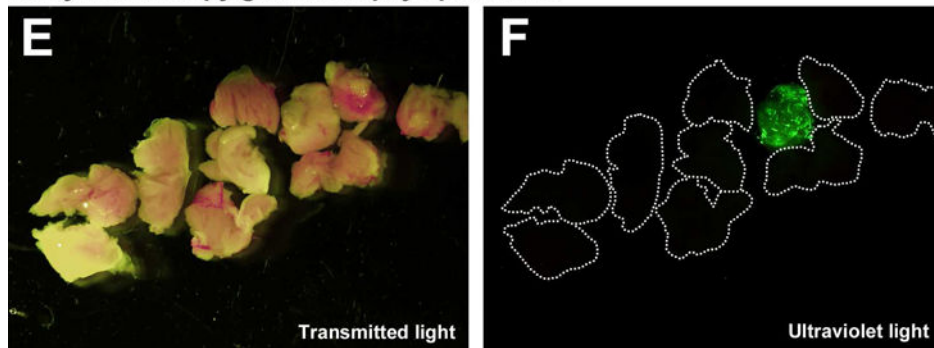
Real-time MRI guided endomyocardial biopsy
